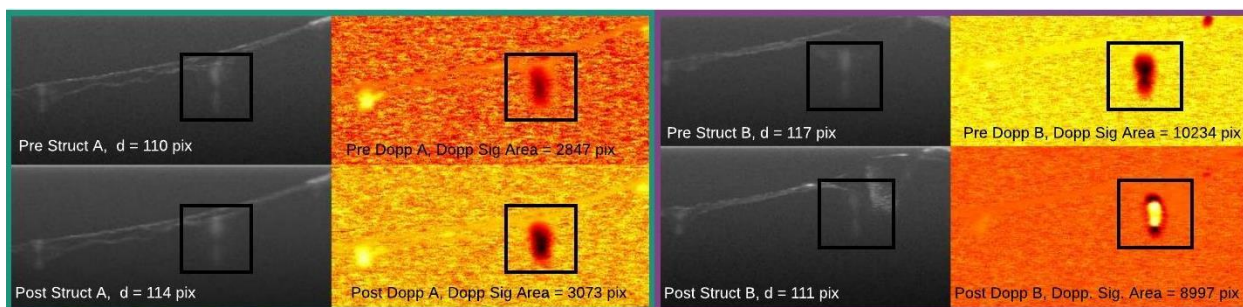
Two examples of unaffected data points. Black boxes indicate the ROI's. Both data point A (green rectangle) and B (purple rectangle) exhibit less than 10% change in vessel diameter and less than 15% change in Doppler Signal Area and thus both of these data points were classified as unaffected. Vessel diameters are labeled in each structural image (d) and are reported in pixels. Doppler Signal Area (Dopp Sig Area) is labeled in each Doppler image and is also given in pixels.
